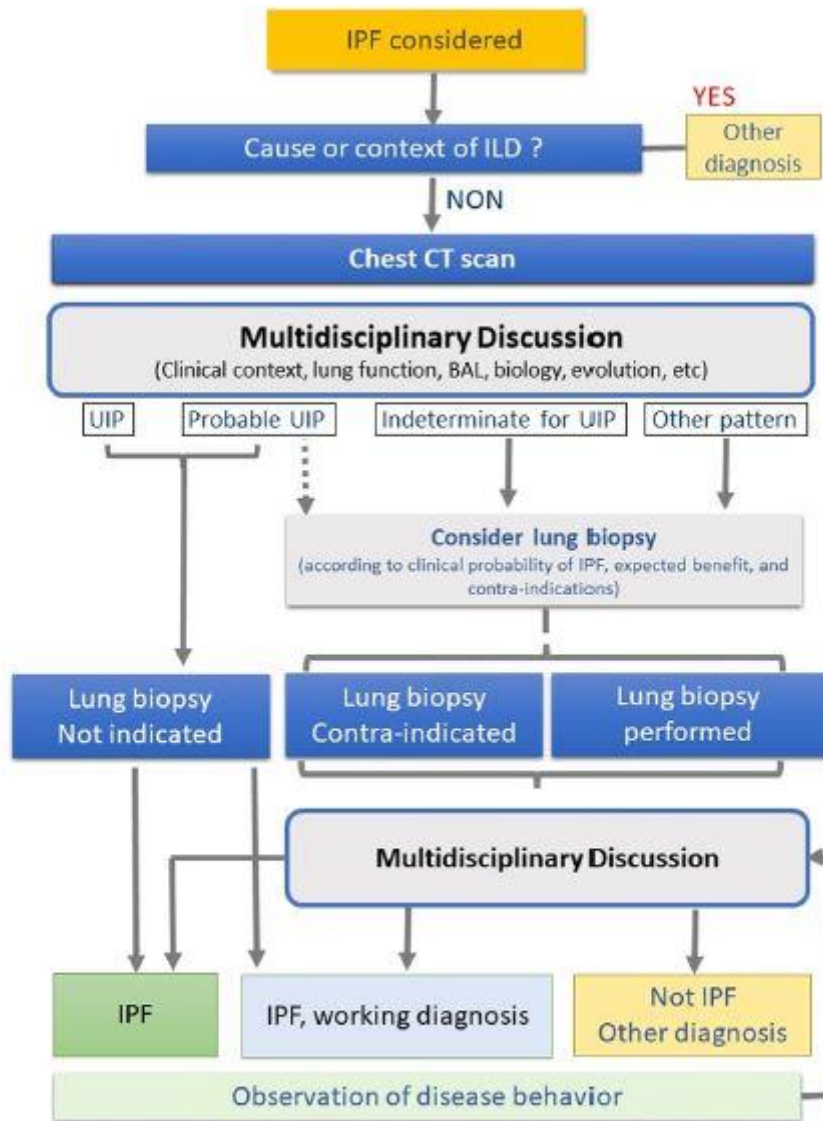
Diagnostic algorithm in a patient with suspected idiopathic pulmonary fibrosis. IPF: idiopathic pulmonary fibrosis; UIP: usual interstitial pneumonia; ILD: interstitial lung disease; CT: computed tomography; provisional working diagnosis: see subchapter "Diagnosis validation".
